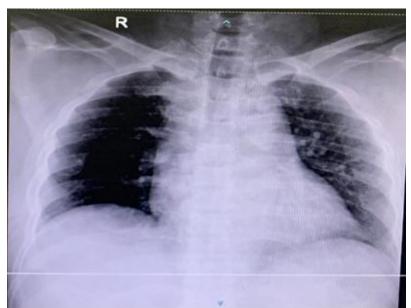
Chest X-ray Results of Chest X-ray on July 2, 2023 showed pneumonia and right pleural effusion.
